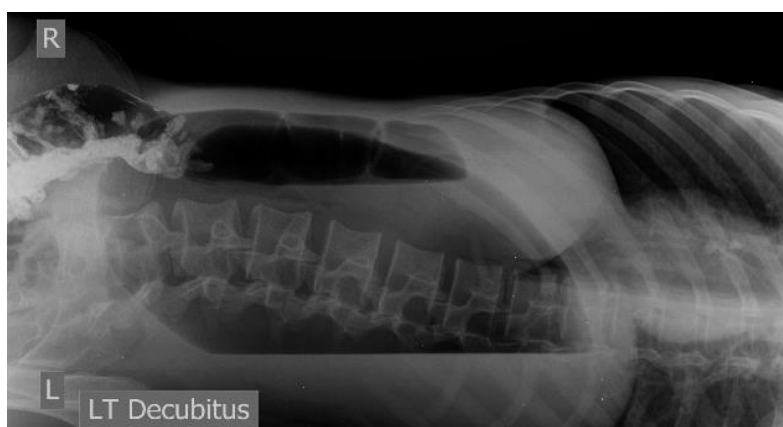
Lateral decubitus radiograph immediately after endoscopic balloon dilation.
